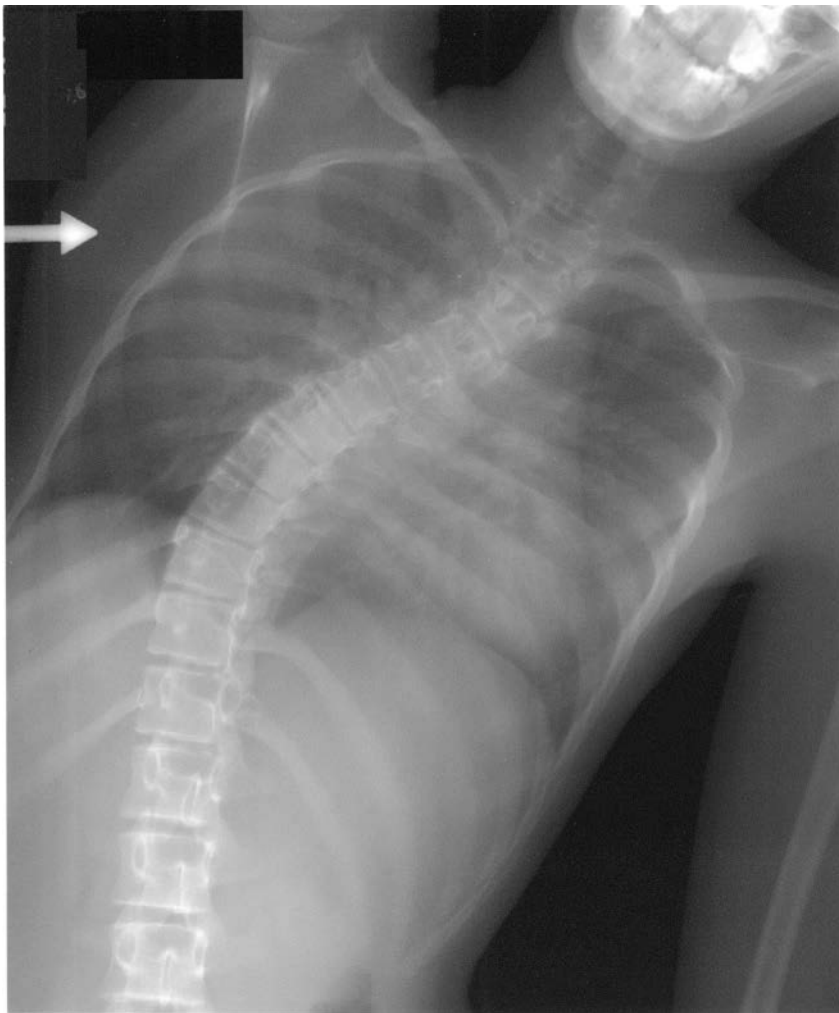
Radiograph of spine demonstrating marked scoliosis.
